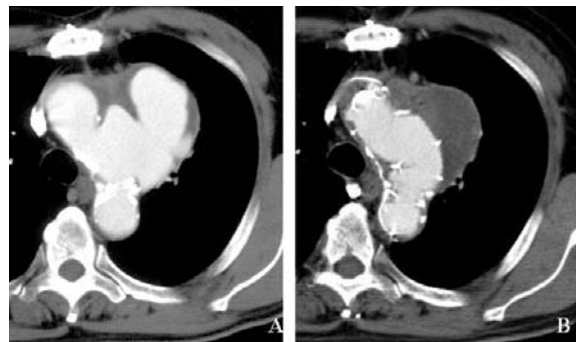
Triple-branched stent-graft for treatment of aortic arch aneurysm. A CT image demonstrates a transverse aortic arch aneurysm. B CT image obtained 2 years after stent-graft placement shows aneurysm shrinkage
